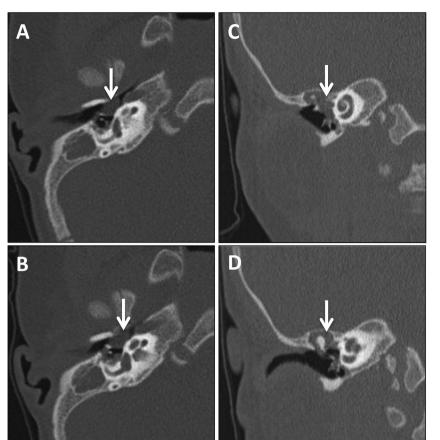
CT temporal bone without contrast. Serial axial cuts starting superiorly (A) to inferiorly (B) demonstrating intact middle ear structures with an effusion and soft tissue density in the right middle ear. Coronal view starting more anteriorly (C) to posteriorly (D) demonstrating the soft tissue density in the anterior epitympanum and anterior superior meso-tympanum. Mass is depicted by white arrow.
